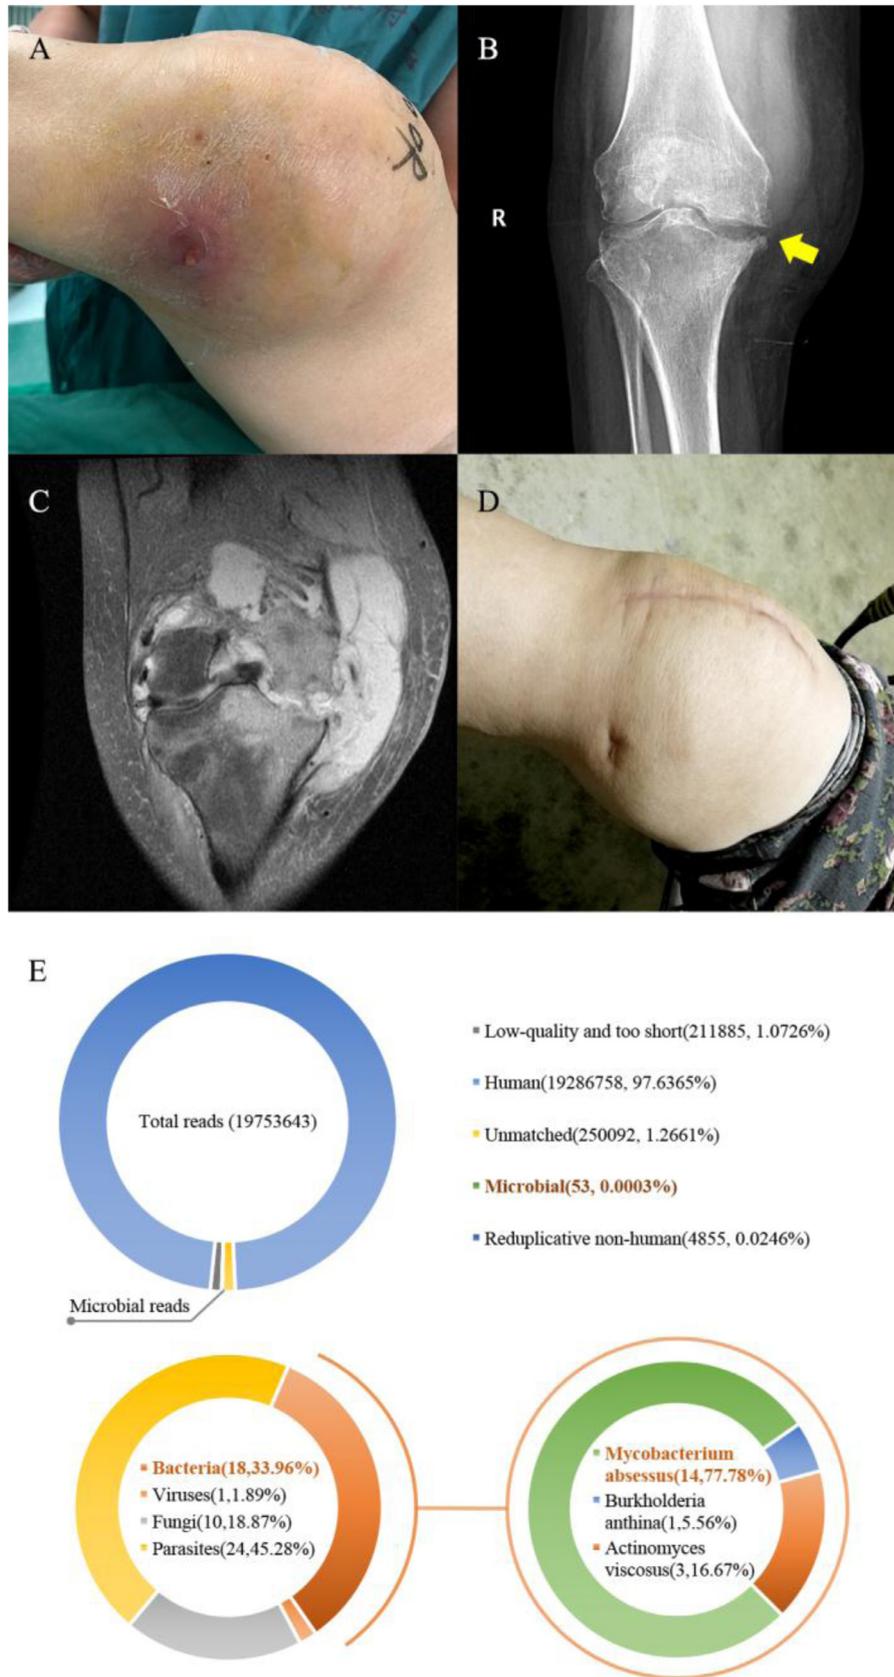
(A) Swollen knee with burst skin before surgery. (B) X-ray film showed destructed medial tibial plateau and femoral condyle of right knee (yellow arrow). (C) A coronal T2-weighted magnetic resonance image of right knee showed massive joint effusion and destructed medial tibial plateau and femoral condyle. (D). The wound healed well without sinus and redness after debridement surgery. (E). The metagenomics next-generation sequencing result revealed *Mycobacterium abscessus* as potential pathogen. Number of mapped reads and percentage in the parentheses. Clinical manifestation, radiological finding and metagenomics next-generation sequencing result of second case.
